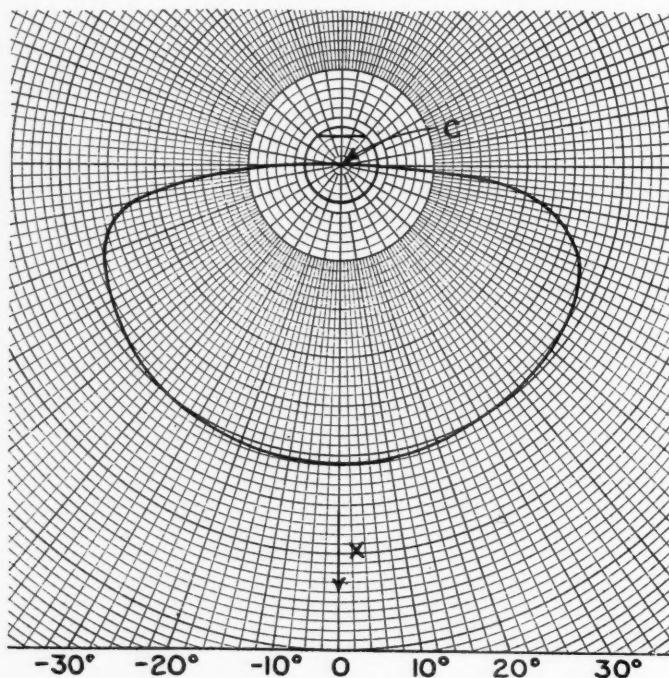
Distribution of energy about 200 K.V. deep therapy X-ray tube target in a plane normal to the tube axis.
